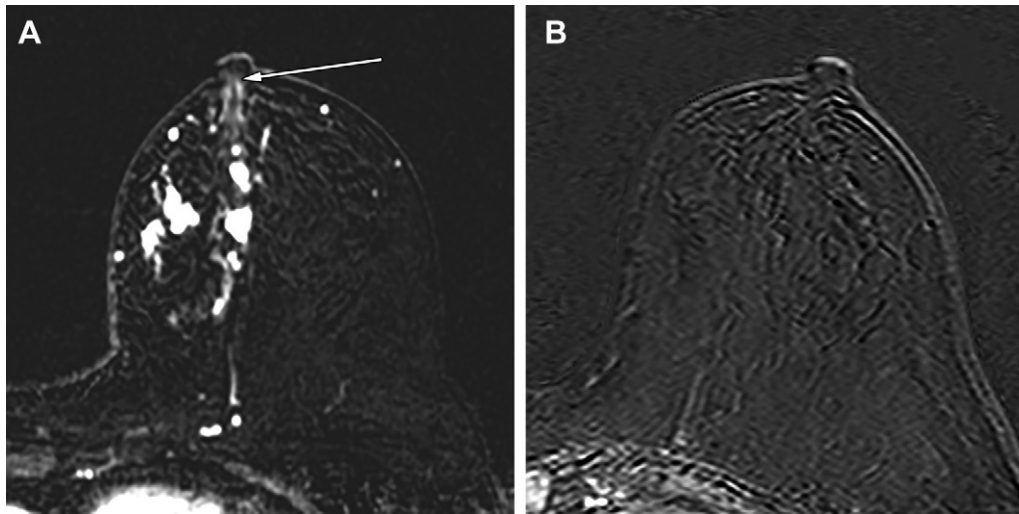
MRI scans in a 72-year-old woman with hormone receptor–negative and human epidermal growth factor 2–positive breast cancer with nonmass enhancement (NME) extension to the nipple at MRI before neoadjuvant chemotherapy (NAC) that appeared to have resolved at MRI after NAC. The patient was administered six cycles of docetaxel, carboplatin, trastuzumab, and pertuzumab every 3 weeks. (A) MRI scans acquired before NAC shows that NME invaded the nipple base (arrow). (B) MRI scans acquired after NAC shows complete response without residual enhancement. Pathologic complete response with the absence of tumor invasion of the nipple was confirmed at pathologic evaluation.
